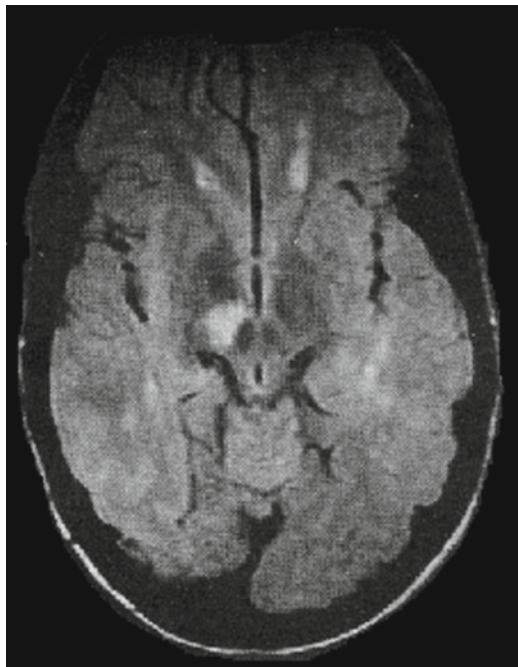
Axial FLAIR and high resolution coronal T2-weighted (reprinted with permission [33])
